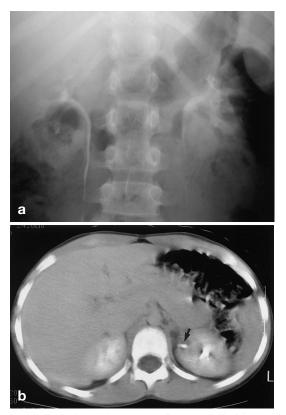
Grossly delayed referral. Nine-year-old girl was always wet despite normal toilet training. Pediatrician was not told until she was seven. Urine cultures all negative. Referred to pediatric urologist at age nine. a EU was finally done and shows subtle signs of left duplex kidney with dysplastic upper pole. The left ureter is further from the spine than the right. b CT scan confirmed presence of ureter draining poorly functioning left upper pole (*arrow*). Left upper pole nephrectomy was performed and she was dry for the first time in her life
